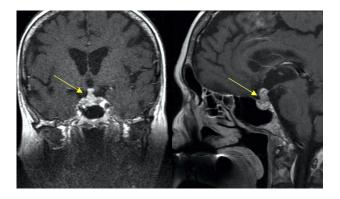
Magnetic resonance imaging in a patient with disseminated neuroendocrine tumour and pituitary stalk metastasis (arrows)
